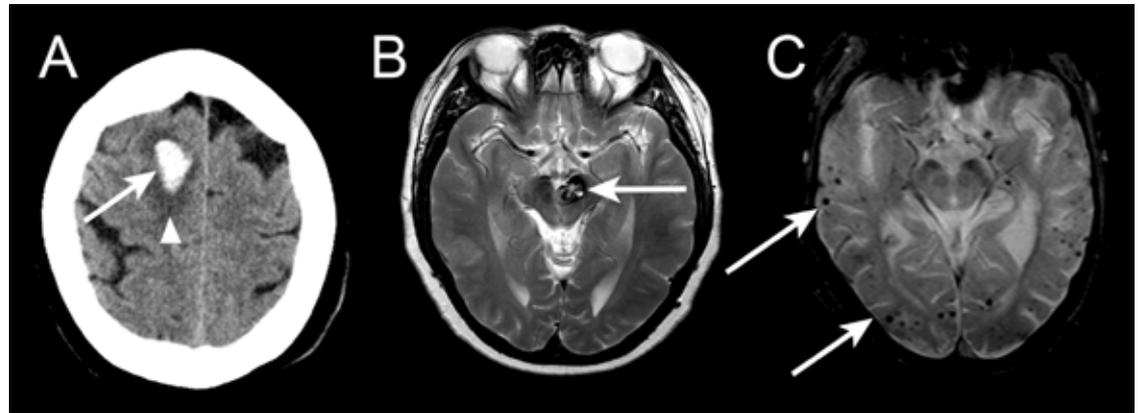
A: Non-contrast computed tomography (CT) head scan revealing acute intracerebral haemorrhage within the right frontal lobe (white arrow) with surrounding oedema (white arrowhead). B: T2 weighted magnetic resonance imaging (MRI) of brain of a patient with intracerebral haemorrhage taken two days after admission confirms a lesion in the left side of the midbrain in the region of the left crus cerebri (white arrow); it shows a peripheral T2 hypointense rim with heterogeneous internal signal, typical of a cavernoma with evidence of recent intralesional haemorrhage. C: T2\* weighted gradient echo MRI of a patient with probable cerebral amyloid angiopathy, showing the widespread, strictly lobar cerebral microbleeds (white arrows), a pattern with high specificity for cerebral amyloid angiopathy
